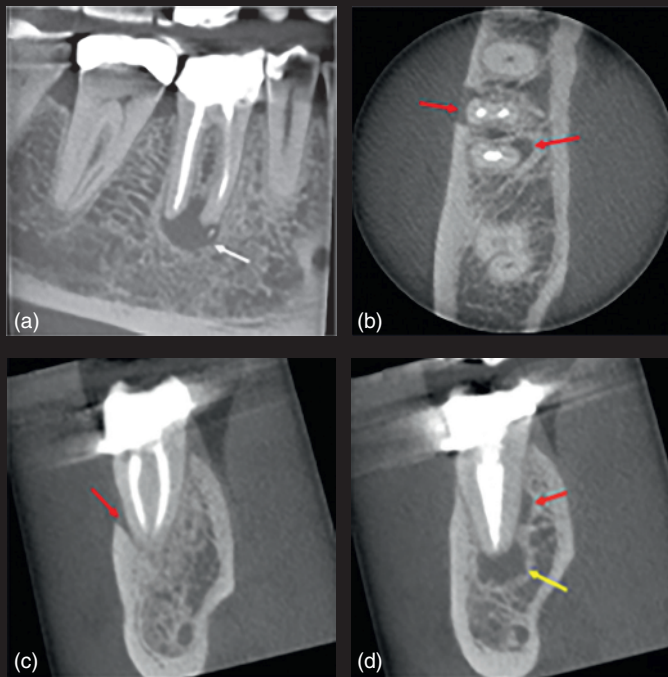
Small field-of-view cone beam computed tomography of tooth LR6. (a) Sagittal image revealed periapical radiolucency (yellow arrow) similar to a periapical radiograph. (b–d) Axial and coronal images revealed separate periradicular radiolucencies (red arrows) at the buccal aspect of the mesial root and lingual aspect of the distal root, which were not continuous with the periapical radiolucency (yellow arrow).
